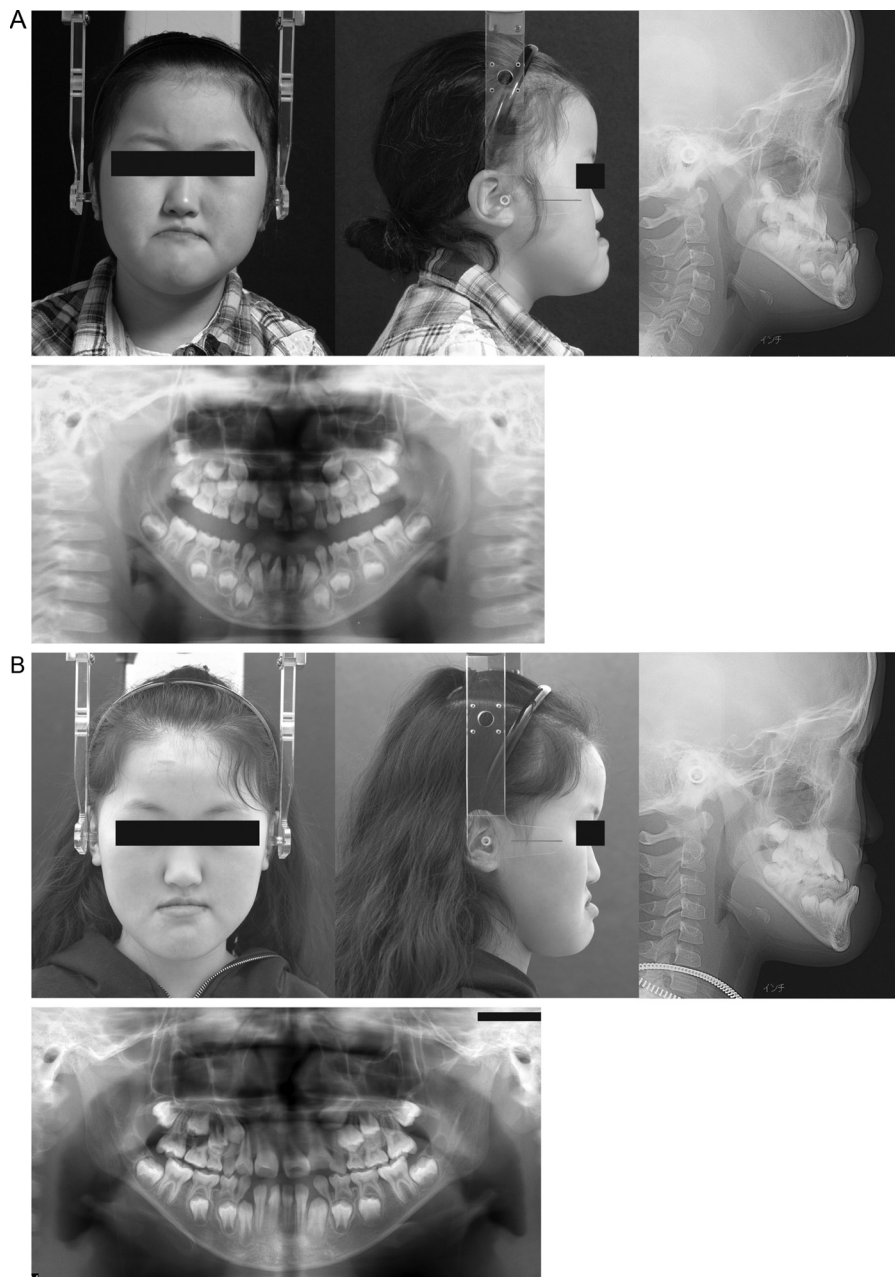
Facial photographs and radiographs: (A) pre-treatment and (B) after 1 year of orthodontic treatment.
